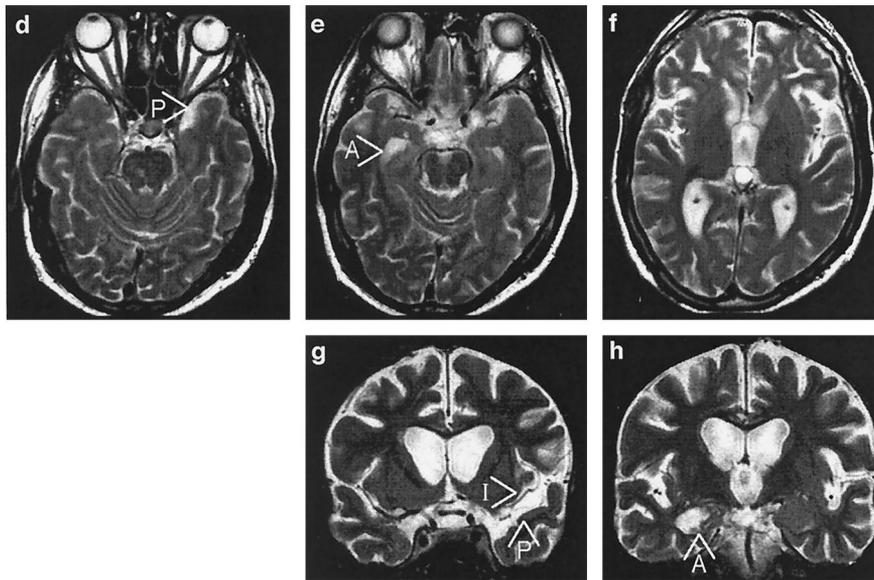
Long-term confabulator (Patient 7). a–c, Acute CT scan after 3 days demonstrates a small hemorrhage lateral of the right amygdala (a) and hypodense areas in the right basal forebrain (b) and the anterior, inferior insula (c). d–h, MRI after 3 years. d–f, Axial T2-weighted scans; g, h, coronal MR scans using the turbo inversion recovery magnitude sequence. There is extensive damage of the right amygdala (e, h), left perirhinal cortex (d, g), and left anterior, inferior insula (h). There is marked atrophy. A = amygdala; B = basal forebrain; I = insula; P = perirhinal cortex.
